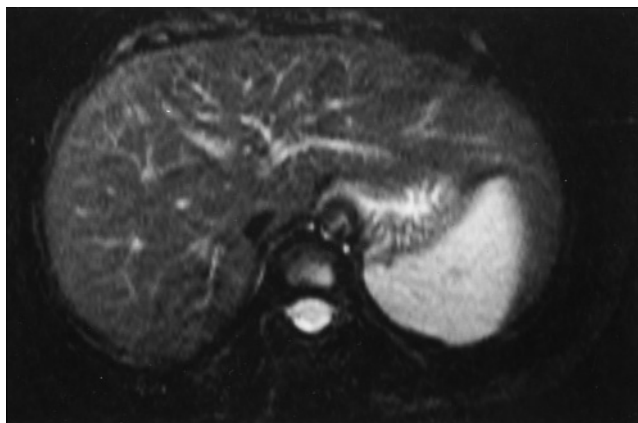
Elongated lateral segment of the left lobe. T2-weighted fat-suppressed ETSE image demonstrates an elongated lateral segment that extends lateral to the spleen. Clear distinction is made between lower-signal-intensity liver and moderately high-signal-intensity spleen on T2-weighted images.
